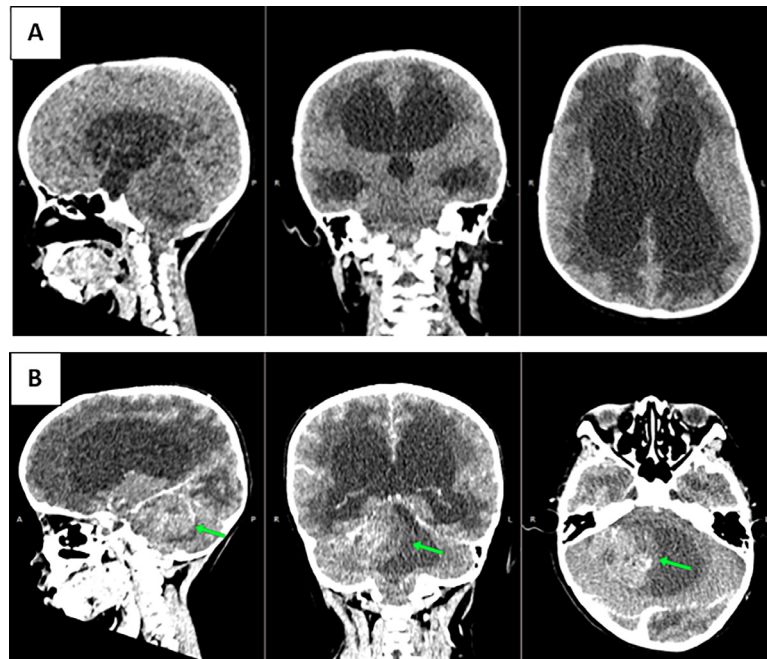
The head CT-scan. (A) Axial, coronal, and sagittal noncontrast head CT scans). The cortical sulci, gyri, bilateral sylvian fissure, and interhemispheric fissure were compressed. There were asymmetry and blunted bilateral lateral ventricles. and (B) CT scan of the head with contrast axial, coronal, and sagittal sections). There was a hypodense periventricular lesion on the anterior and posterior cornu of the bilateral lateral ventricles. There was a well-circumscribed isodense mass with inner hypodense component and a regular edge originating from the cerebellum measuring $3.60 \times 4.55 \text{ cm} \times 4.43 \text{ cm}$, compressing the fourth ventricle and right cerebellum with postcontrast rim enhancement. The basal cisterns and ambience were dilated.
